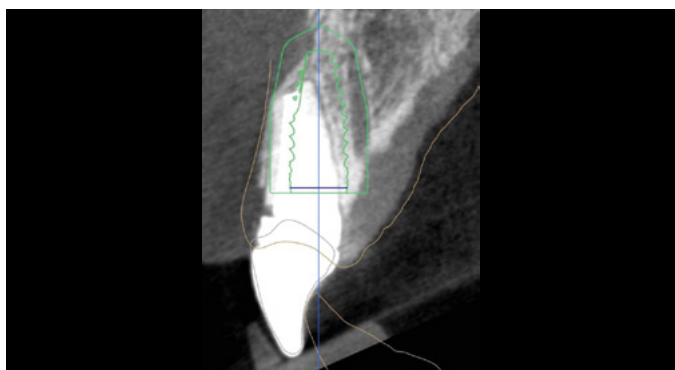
Implant planning with CBCT
